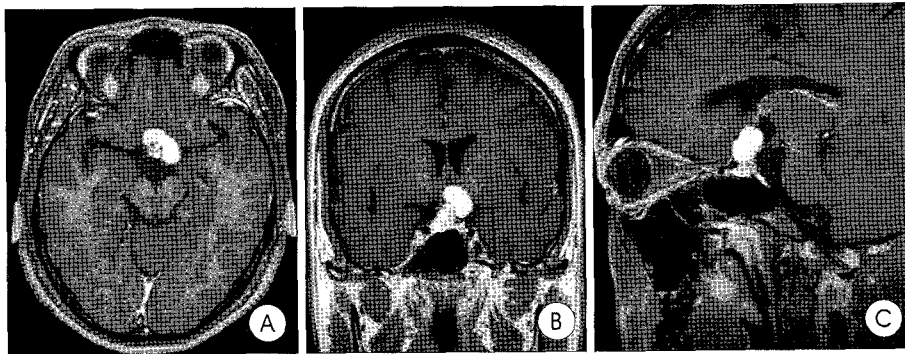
1.5mm-thin sliced magnetic resonance images showing a sellar and suprasellar mass (A, B & C). The suprasellar mass upwardly indenting upon the floor of third ventricle.
